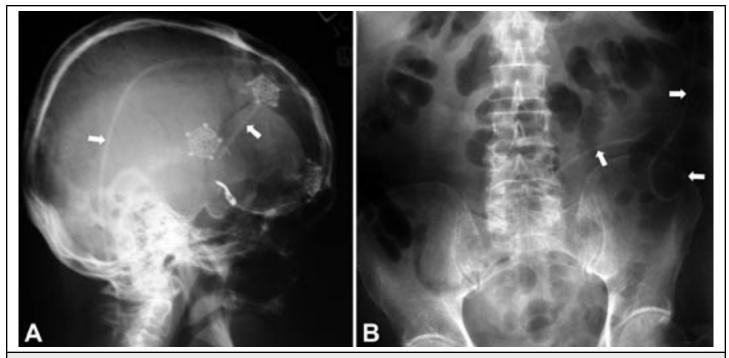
A. Radiograph of the Head with the Course of the VP Shunt Indicated by the Arrows; B. Radiograph of the Abdomen with the VP Shunt (indicated by the arrows) Seen on the Patient's Left Side with the Intraperitoneal Yip at the Midline
